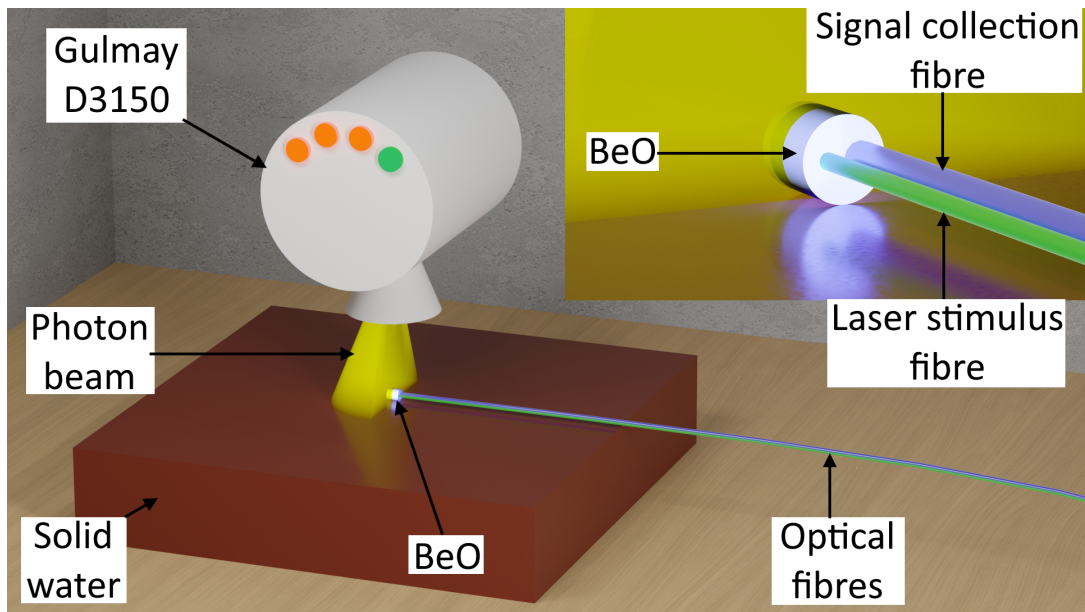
3D model of the superficial X-ray measurement setup with a cutaway in the photon beam to show the BeO dosimeter (not to scale). Close up of the BeO ceramic volume and optical fibres is shown in the top right corner. Published in Madden *et al.* [209].
